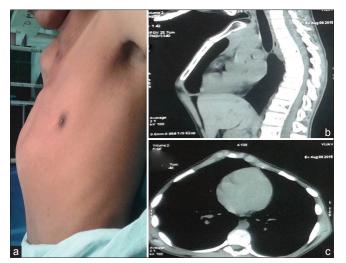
(a) Image of the patient chest showing pectus carinatum. (b and c) computed tomography scan chest of the patient (sagital and transverse sections, respectively) showing pectus carinatum
